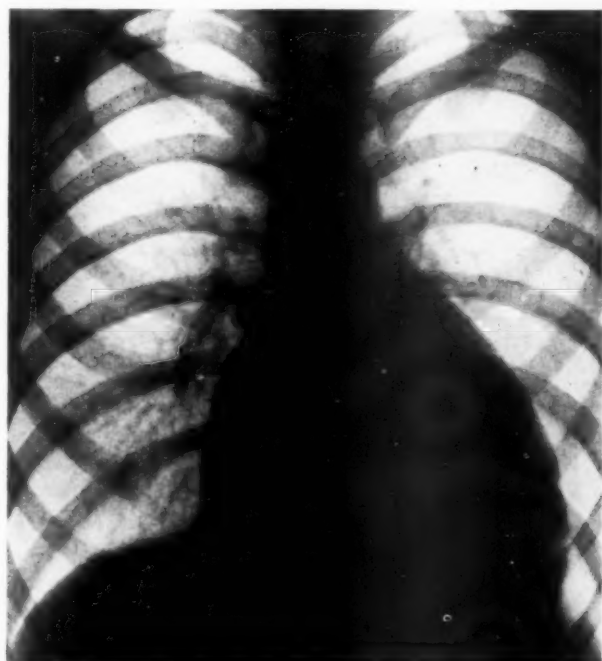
(Case 1).—Plain roentgenogram of chest which indicates a large globular heart, large right auricle, and (?) right ventricle; Pulmonary arteries are not enlarged, and lungs are underfilled.
